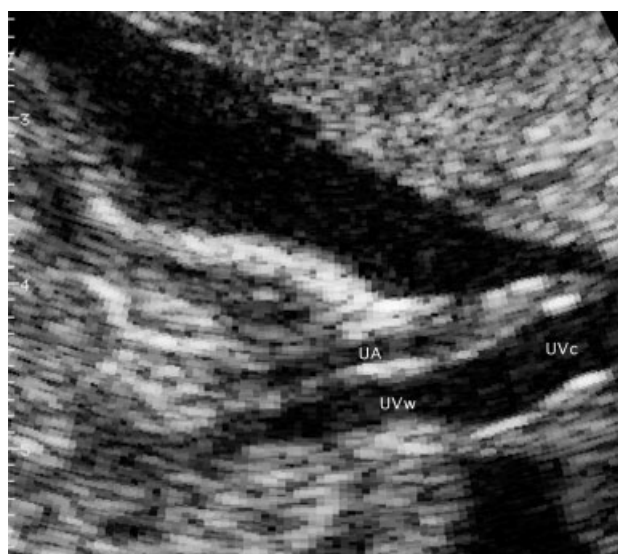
Ultrasound scan of the junction of the cord at the fetal abdominal wall at 21 weeks of gestation showing the umbilical vein in the cord (UVc) and the constricted portion of the vein at the abdominal wall (UVw). UA, Umbilical artery
